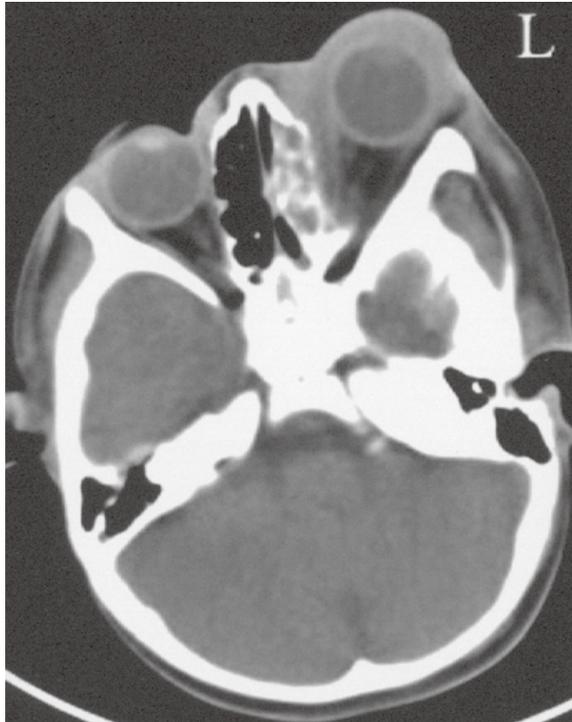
Axial CT image shows left ethmoid sinusitis with orbital cellulitis.
